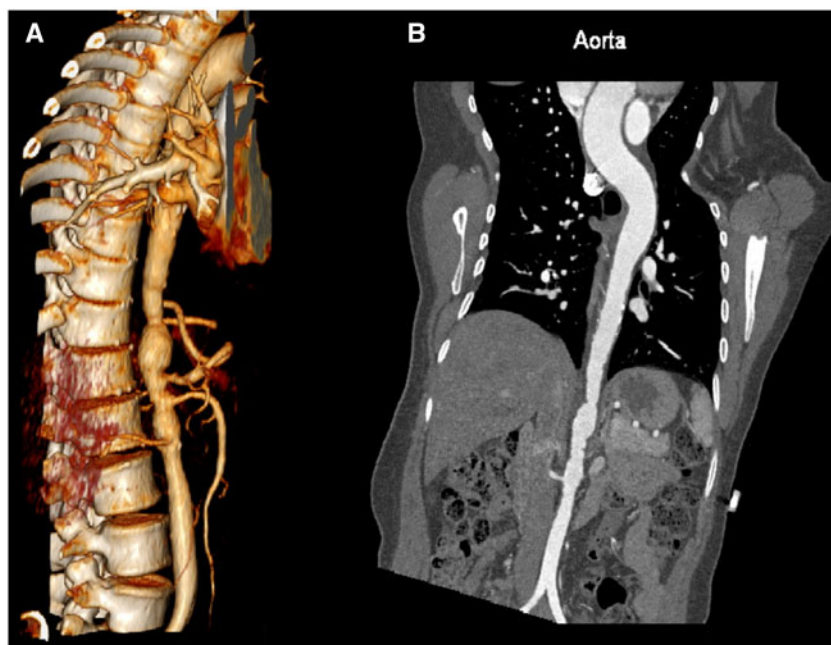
(A) Aortic computed tomography with three-dimensional reconstruction of descending and abdominal aorta; (B) two-dimensional view.
